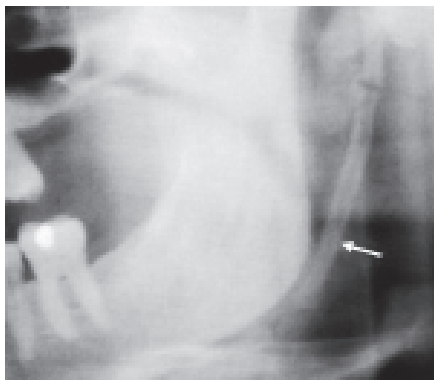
Showing part of a panoramic radiograph showing a long calcified stylohyoid ligament (arrowed), a feature of Eagle's syndrome
